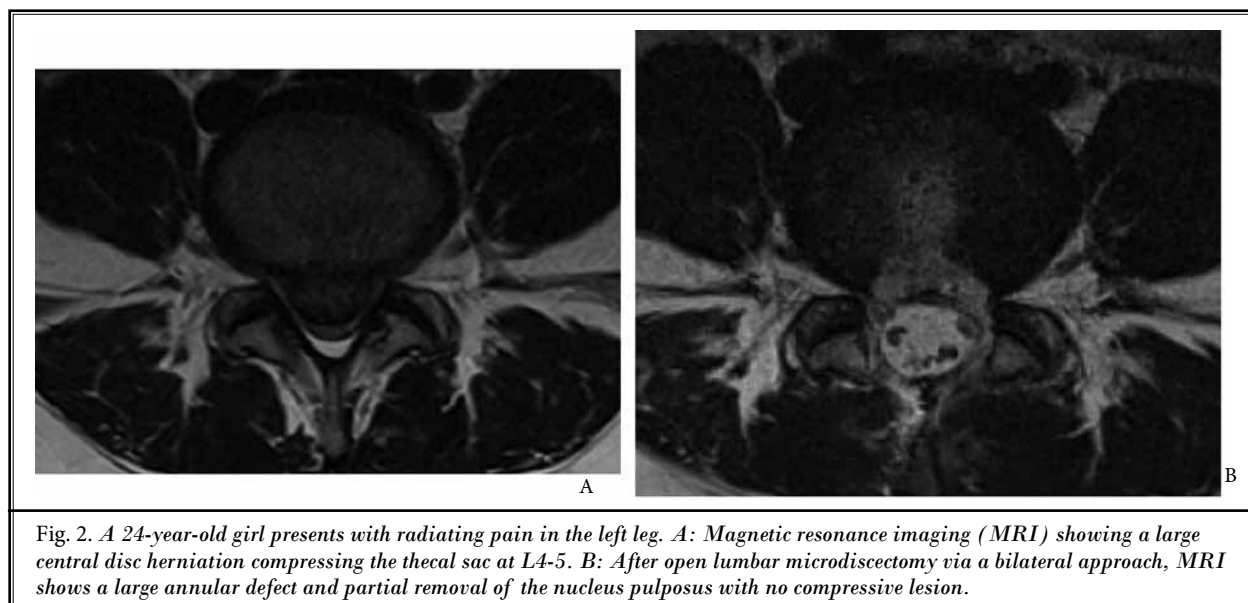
A 24-year-old girl presents with radiating pain in the left leg. A: Magnetic resonance imaging (MRI) showing a large central disc herniation compressing the thecal sac at L4-5. B: After open lumbar microdiscectomy via a bilateral approach, MRI shows a large annular defect and partial removal of the nucleus pulposus with no compressive lesion.
